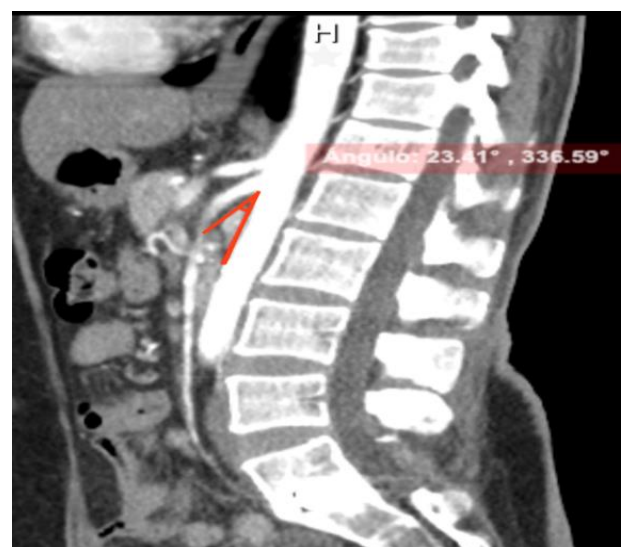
Abdominal computed tomography in sagittal projection with contrast in the arterial phase, a decrease in the aortomesenteric angle of 23.41° is observed.
